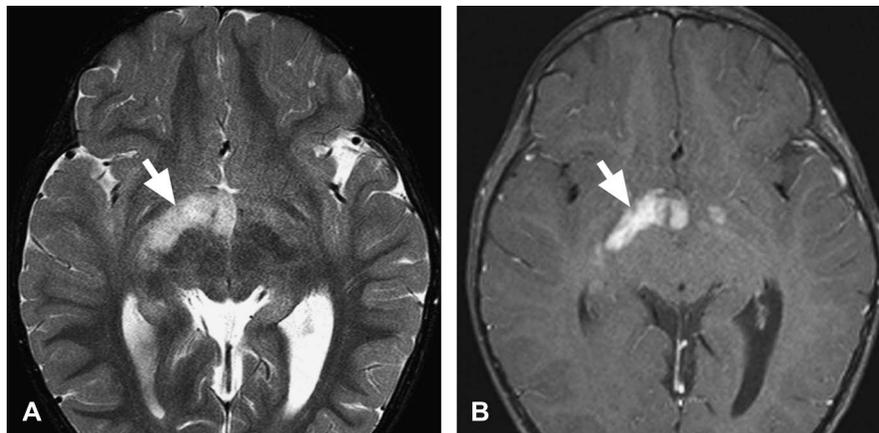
OPG involving the right optic tract (arrow) on T2 axial (A) and contrast-enhanced T1 (B) MRI.
